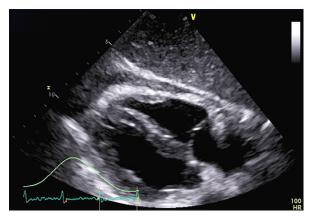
Transthoracic echocardiogram (subcostal 4-chamber view) shows thickened pericardium. Ventricular interdependence (septal bounce) was seen on real-time images.
